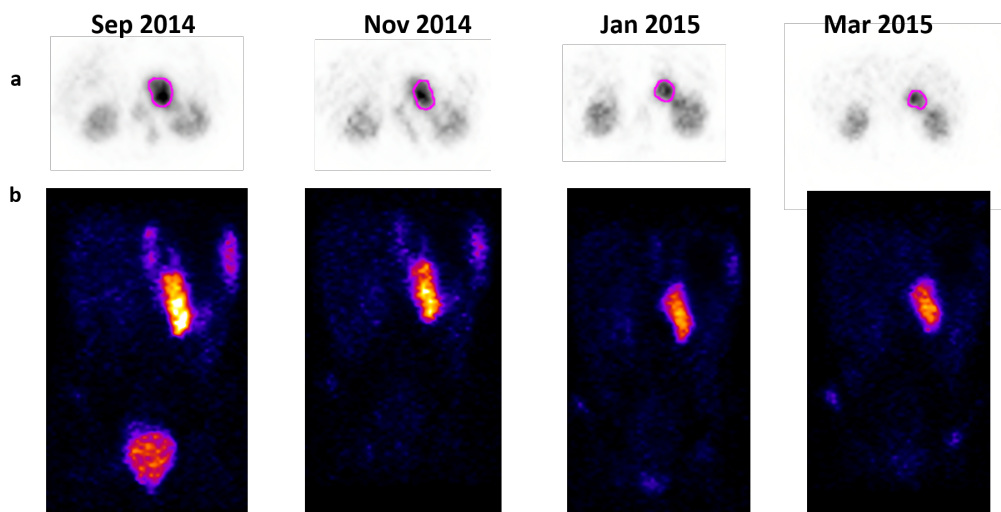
Longitudinal SPECT/CT at 24h after each cycle of ^{177}Lu -DOTATATE showing reduction in max uptake of lesion for patient 001. Patient 001 showed Stable Disease. She had a stable response during the treatment course as seen on a) coronal and b) axis SPECT slices
